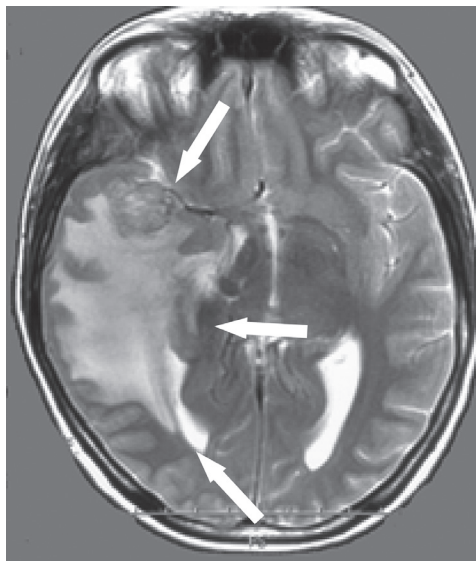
Axial view of T2-weighted MRI reveals a well-demarcated isotense temporal tumor with severe peritumoral edema (marked with arrows), graded with III in Steinhoff classification [7, 11].
